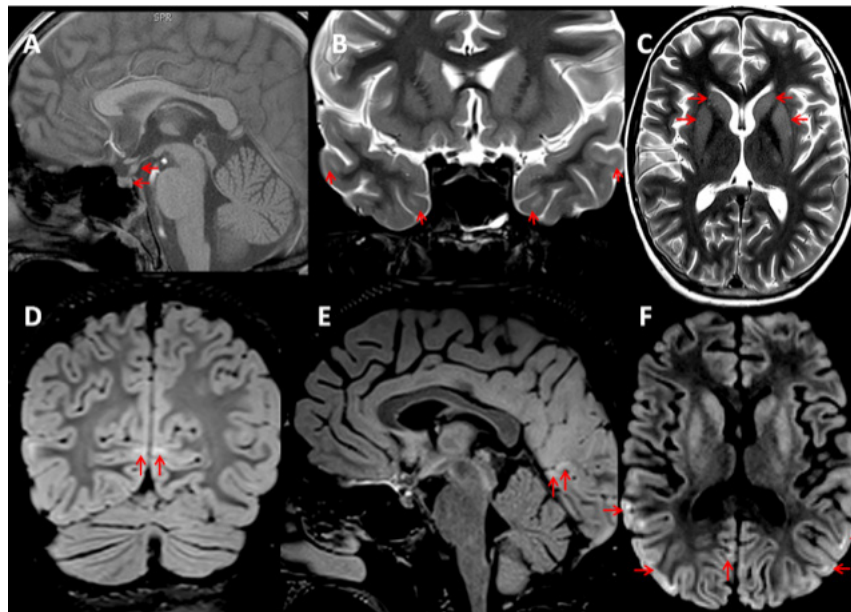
(A-F): Brain MRI. (A) Sagittal T1WI showing pituitary stalk thickening and absence of the posterior pituitary bright spot (B) Coronal T2WI showing subcortical U fiber hyperintensity in the anterior temporal lobes (C) Axial T2WI showing hyperintensity in the corpus striatum bilaterally (D-E) Coronal and Sagittal FLAIR showing hyperintensity in the subcortical white matter of the cuneus of both occipital lobes at the superior margins of the calcarine fissure (primary visual cortex). (F) Axial trace DWI showing restricted diffusion in the subcortical U fibers in both occipital lobes, including the right primary visual cortex.
